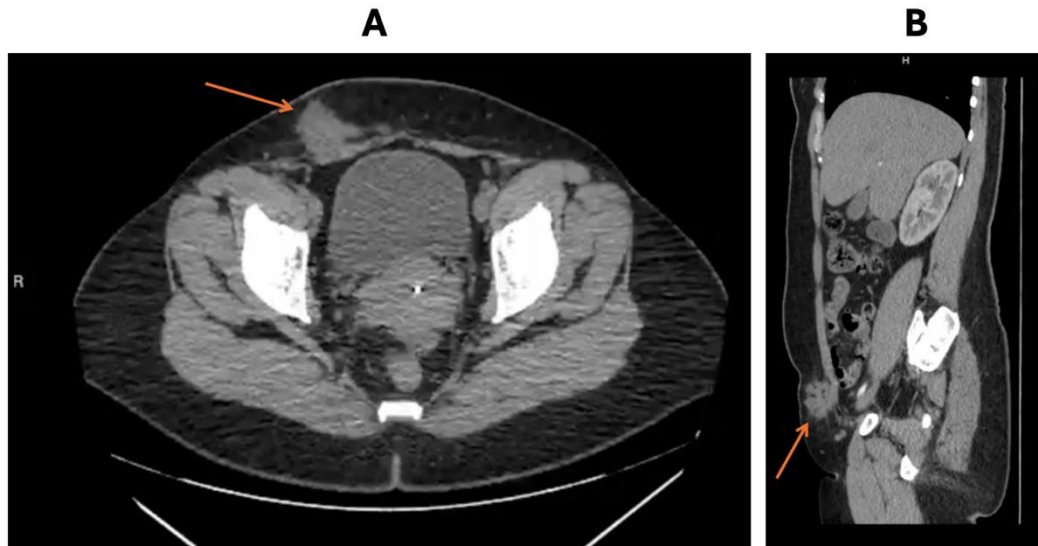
Axial (A) and Sagittal (B) CT scan showing a soft tissue mass ($8.2 \times 4.6 \times 4.5$ cm) involving the right rectus abdominis and projecting into suprapubic subcutaneous tissue.
